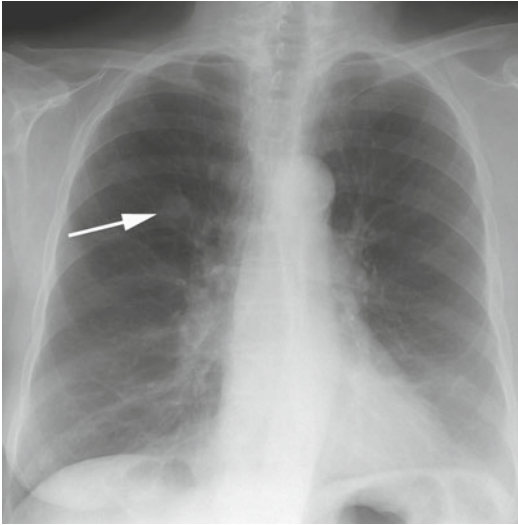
Frontal chest radiograph reveals 2 cm right upper lobe solitary pulmonary nodule (*arrow*)
